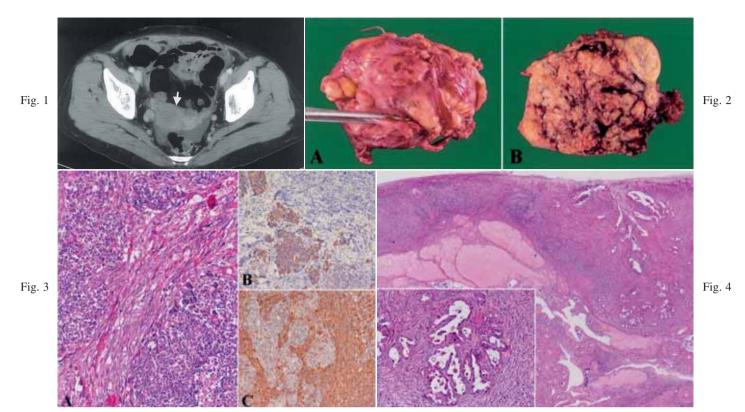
Computed tomography revealed a large tumor in the right side of the pelvis (arrow head).
